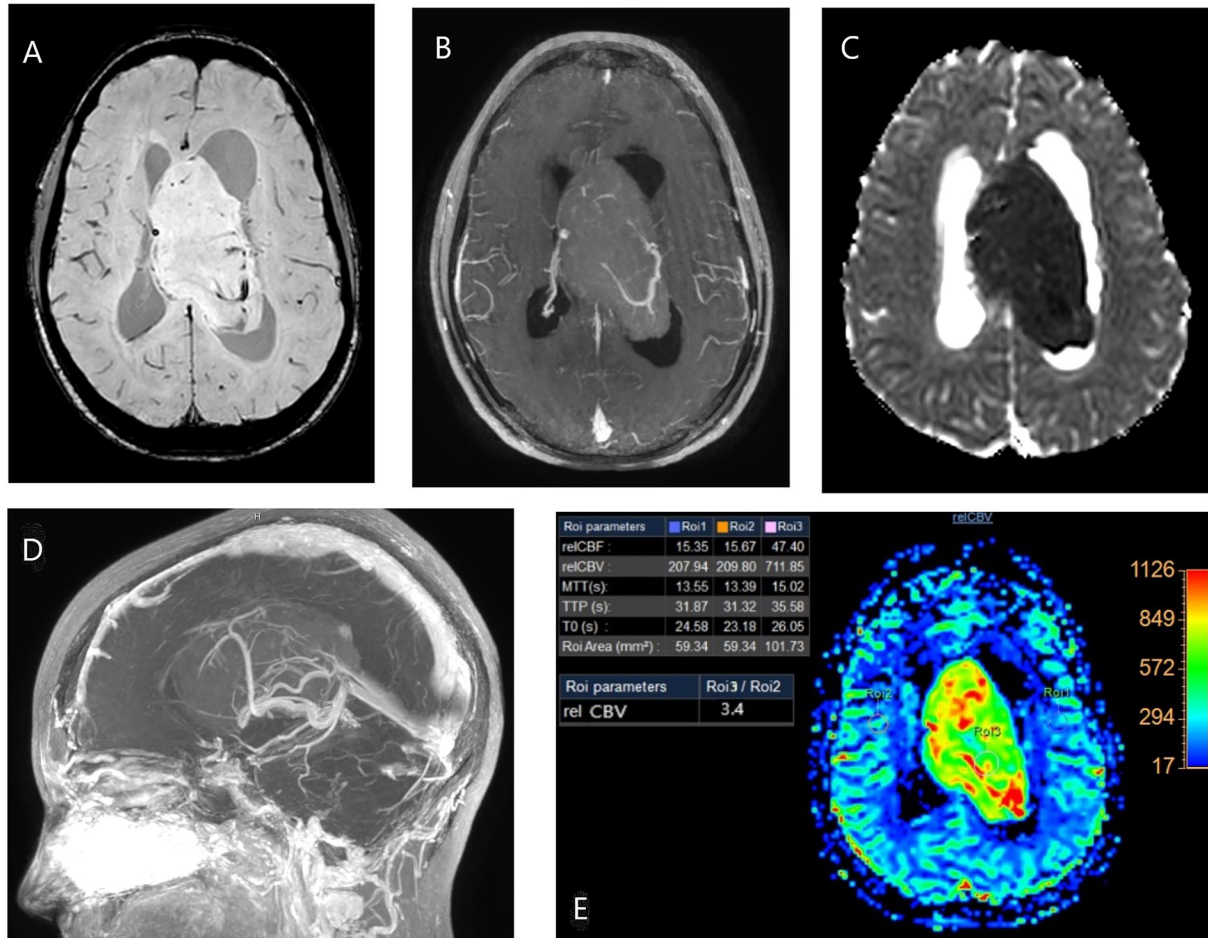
Brain MRI. (A) Susceptibility image with hypointensities inside the lesion corresponding to calcification and void of signal of the vessels. (B) contrast image with moderate enhancement (C) ADC image with significant restriction (D) 3D reconstruction demonstrates important drainage to the deep venous system. (E) Perfusion with increased vascularity inside the lesion.
